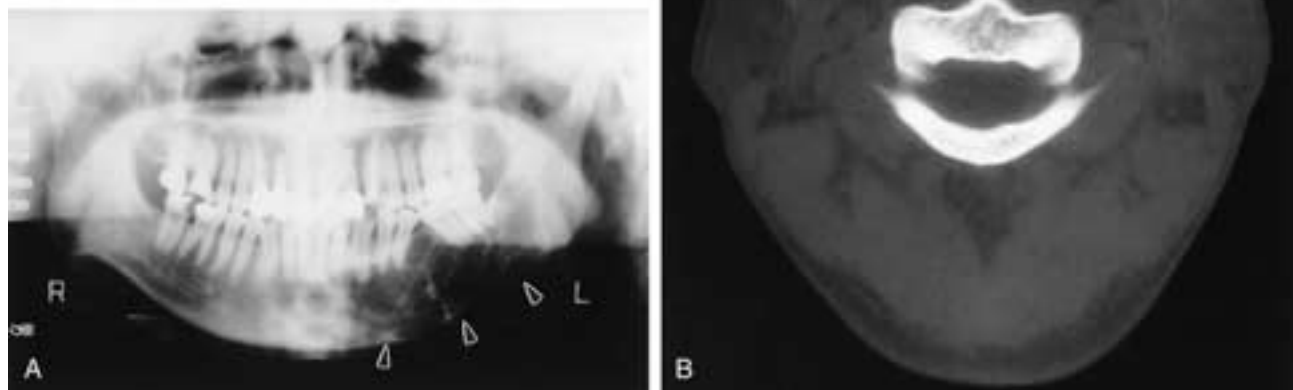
Myxoma of the mandible. A, Pantomogram shows an ill-defined lesion with straight septa and tooth displacement (*arrowheads*). B, Axial CT (bone window setting) shows buccal expansion of the lesion with straight septa (*arrow*).
